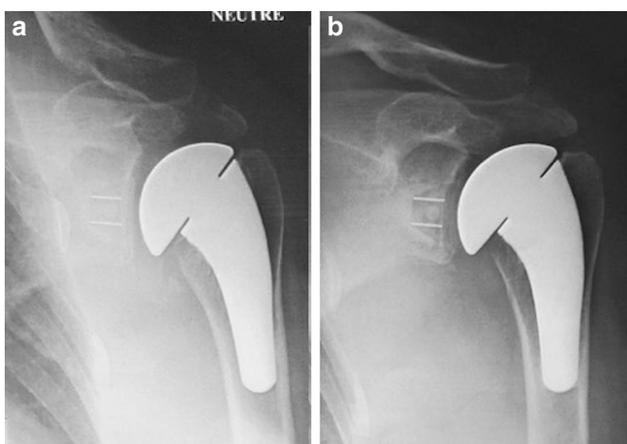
70-year-old patient with low bone adaptations at the immediate postoperative radiograph (a) and at 48-month follow-up (b)
